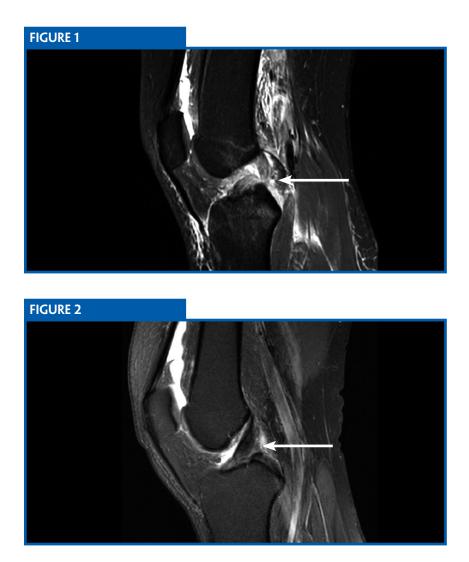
a sagittal view of the MRI of the patient's right knee, reveals a complete midsubstance tear of the anterior cruciate ligament (ACL). ACL tears are the most frequent cause of extended absence from participation in sports.¹ They commonly occur in deceleration and rotational movements during running, jumping, or cutting. The ligament helps maintain the stability of the knee by preventing anterior translation of the tibia. In the examination of a patient with a suspected ACL tear, the Lachman test is the most useful. The test is performed with the patient supine and the knee in 20° to 30° of flexion as the examiner applies an anterior force to the tibia with one hand, while using the other hand to stabilize the distal femur.² During the test, the hamstring must be relaxed in order to prevent a falsenegative result. Anterior translation of the tibia with a soft end point during the Lachman test is diagnostic of an ACL tear. This patient was scheduled for right knee arthroscopy with ACL repair. Figure 2 is a sagittal view of an MRI completed in a patient with an intact ACL.
